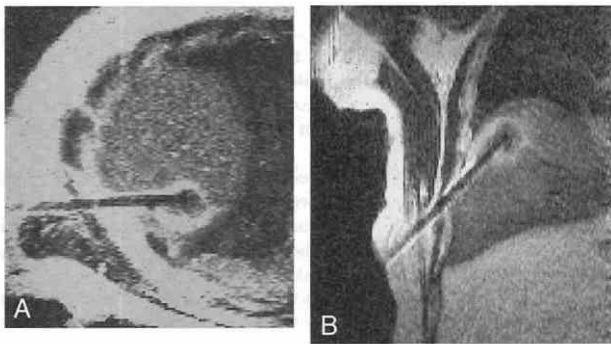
Turbo spin-echo T2-weighted oblique axial (A) and coronal (B) images obtained during MRI-guided radiofrequency (RF) thermal ablation. During the ablation session, T2-weighted and STIR images allow assessment of the developing zone of tissue damage, seen as a hypointense region surrounded by a bright ring of edema at the tip of the RF electrode. These images are intermittently acquired during the ablation session to ensure ablation of the entire tumor and thin rim of surrounding normal tissue.
